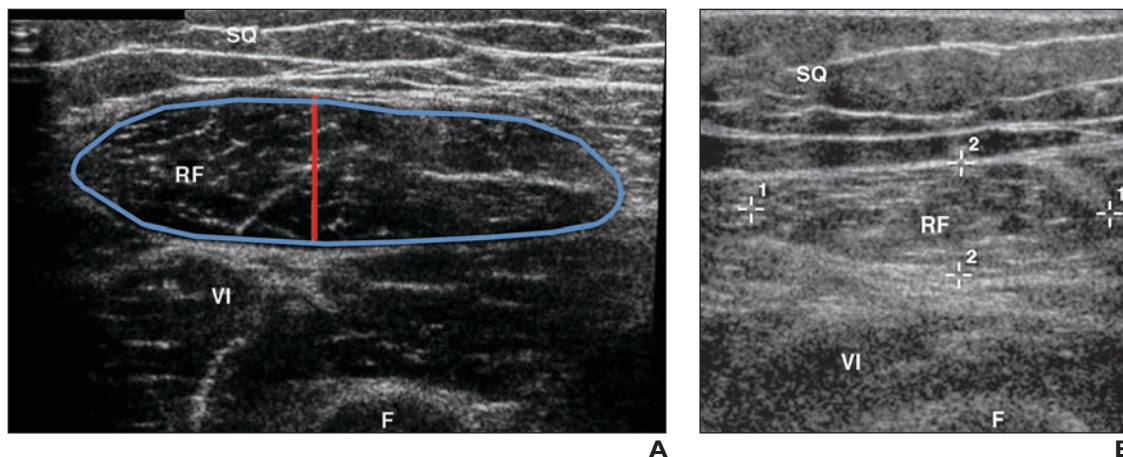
Ultrasound measurements of muscle size used as regional markers of sarcopenia in two different subjects. (Courtesy of Rider L)
